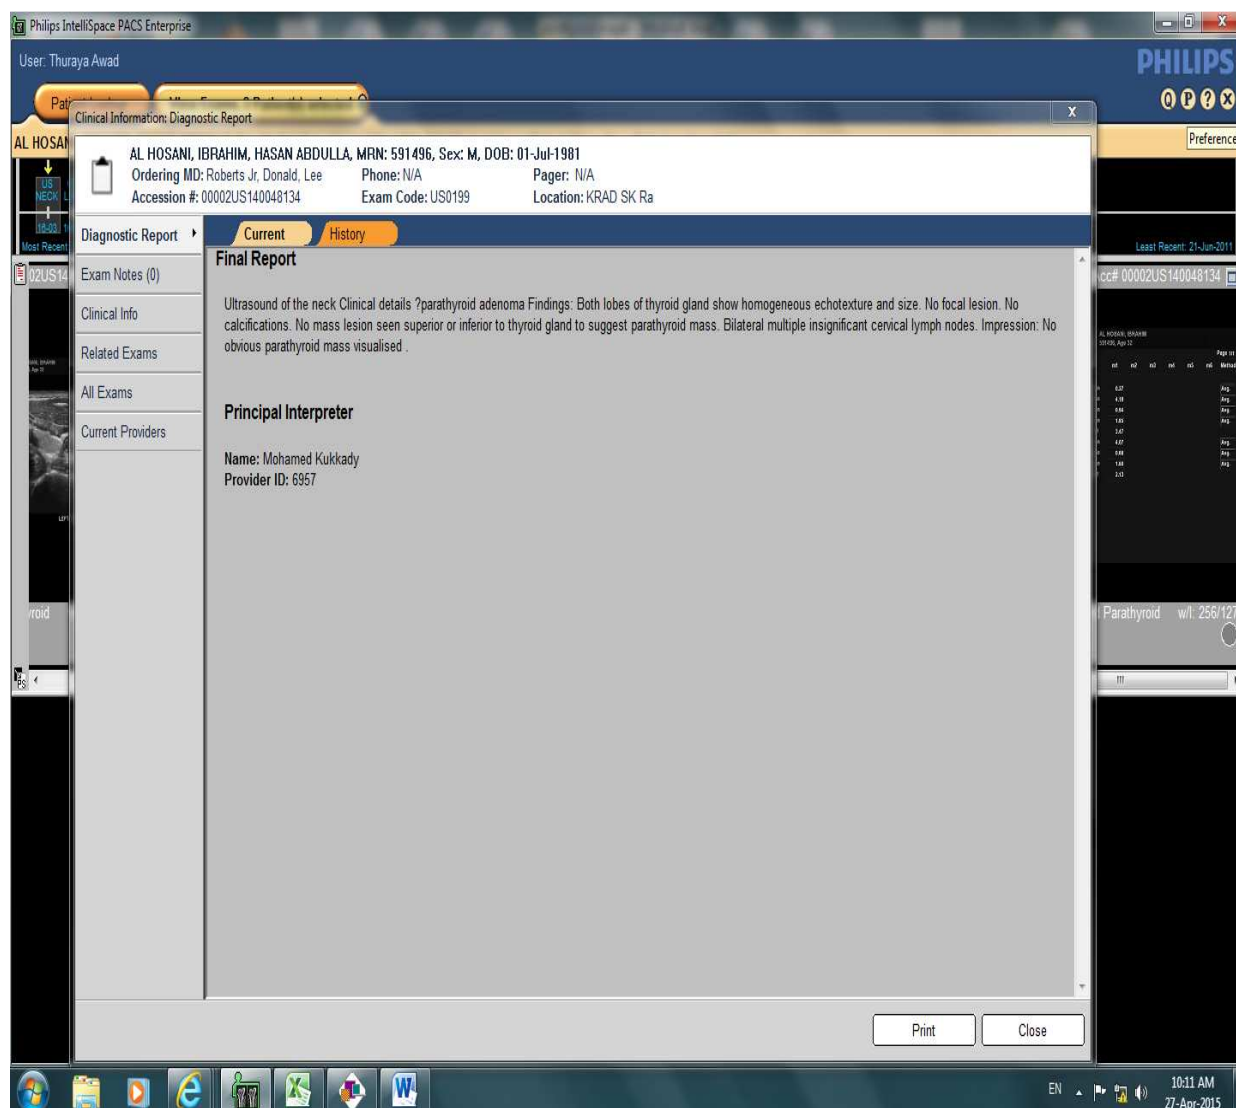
Figure A-3 ultrasound report for figure A-1 and A-2
